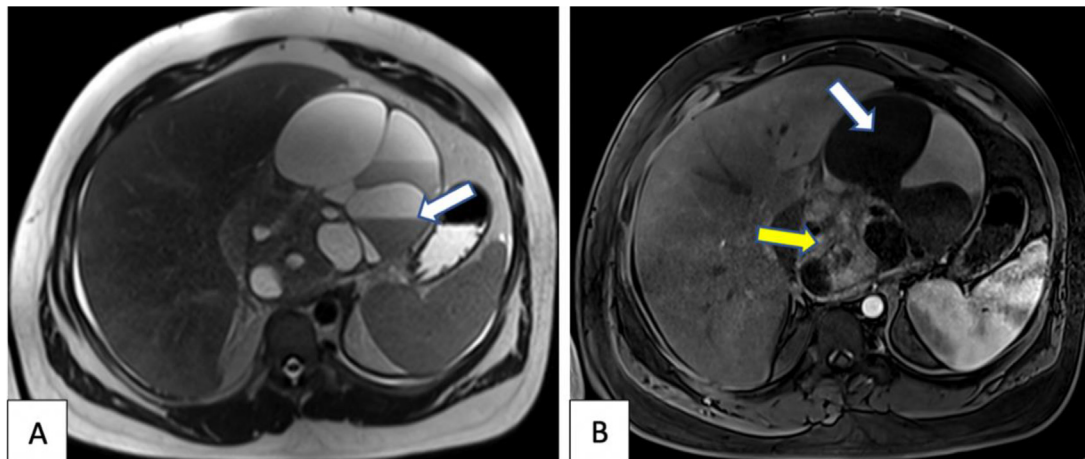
MR imaging with axial T2WI (A) and Axial T1 fatsat, post Gadolinium injection, arterial phase (B). (A) shows the tumor includes hyperintense part of the fluid and hypointense part due to bleeding, forming the fluid- blood sign (arrow), in addition the intermediate signal of soft tissue corresponding to the strong and heterogeneous enhancing part (yellow arrow, B). (B) shows the non-enhanced hypointense fluid part after Gadolinium injection (white arrow). No lesion of the spine as well as the spinal canal was seen.
